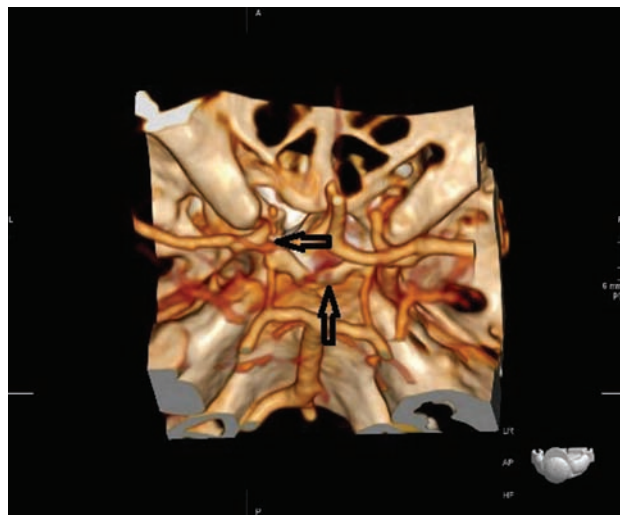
CT angiogram of circle of Willis shows an occluded left ICA and a narrowed right MCA (arrows show narrowed MCA and ICA). CT = computed tomography; ICA = internal carotid artery; MCA = middle cerebral artery.
